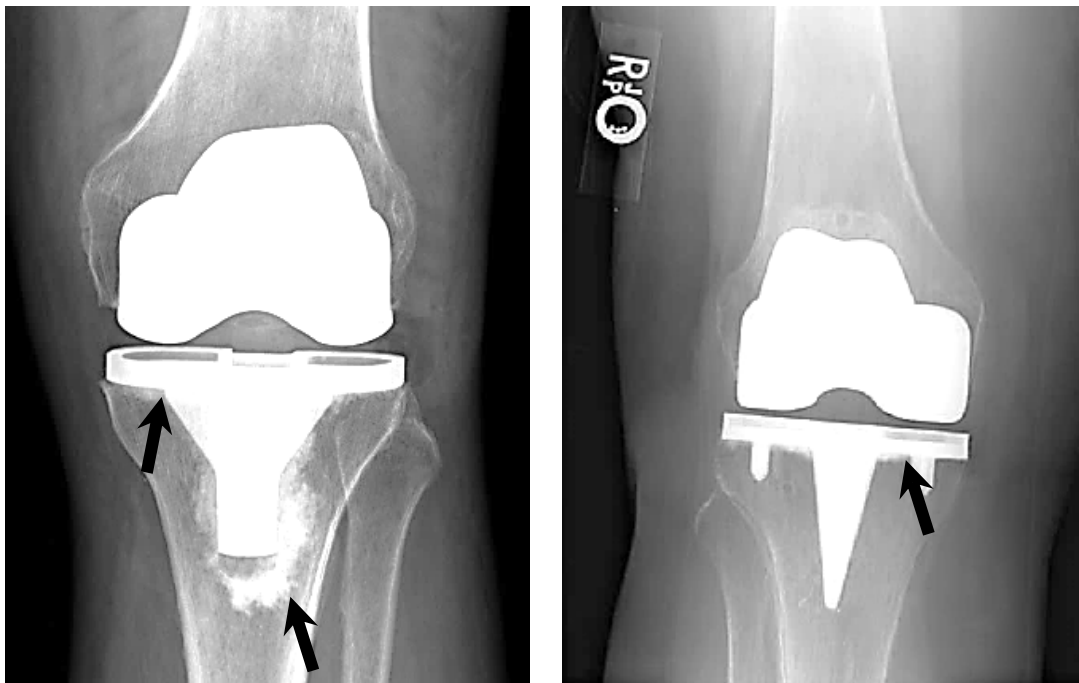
Radiographic scans of cemented tibial trays, cement is indicated with arrows. Left: Full cementation with cement layer covering stem, keels and back side of the tray [scan provided by University Hospital Heidelberg]. Right: Plateau-only cementation leaving the stem cementless [adapted from Hofmann *et al.*¹⁶].
